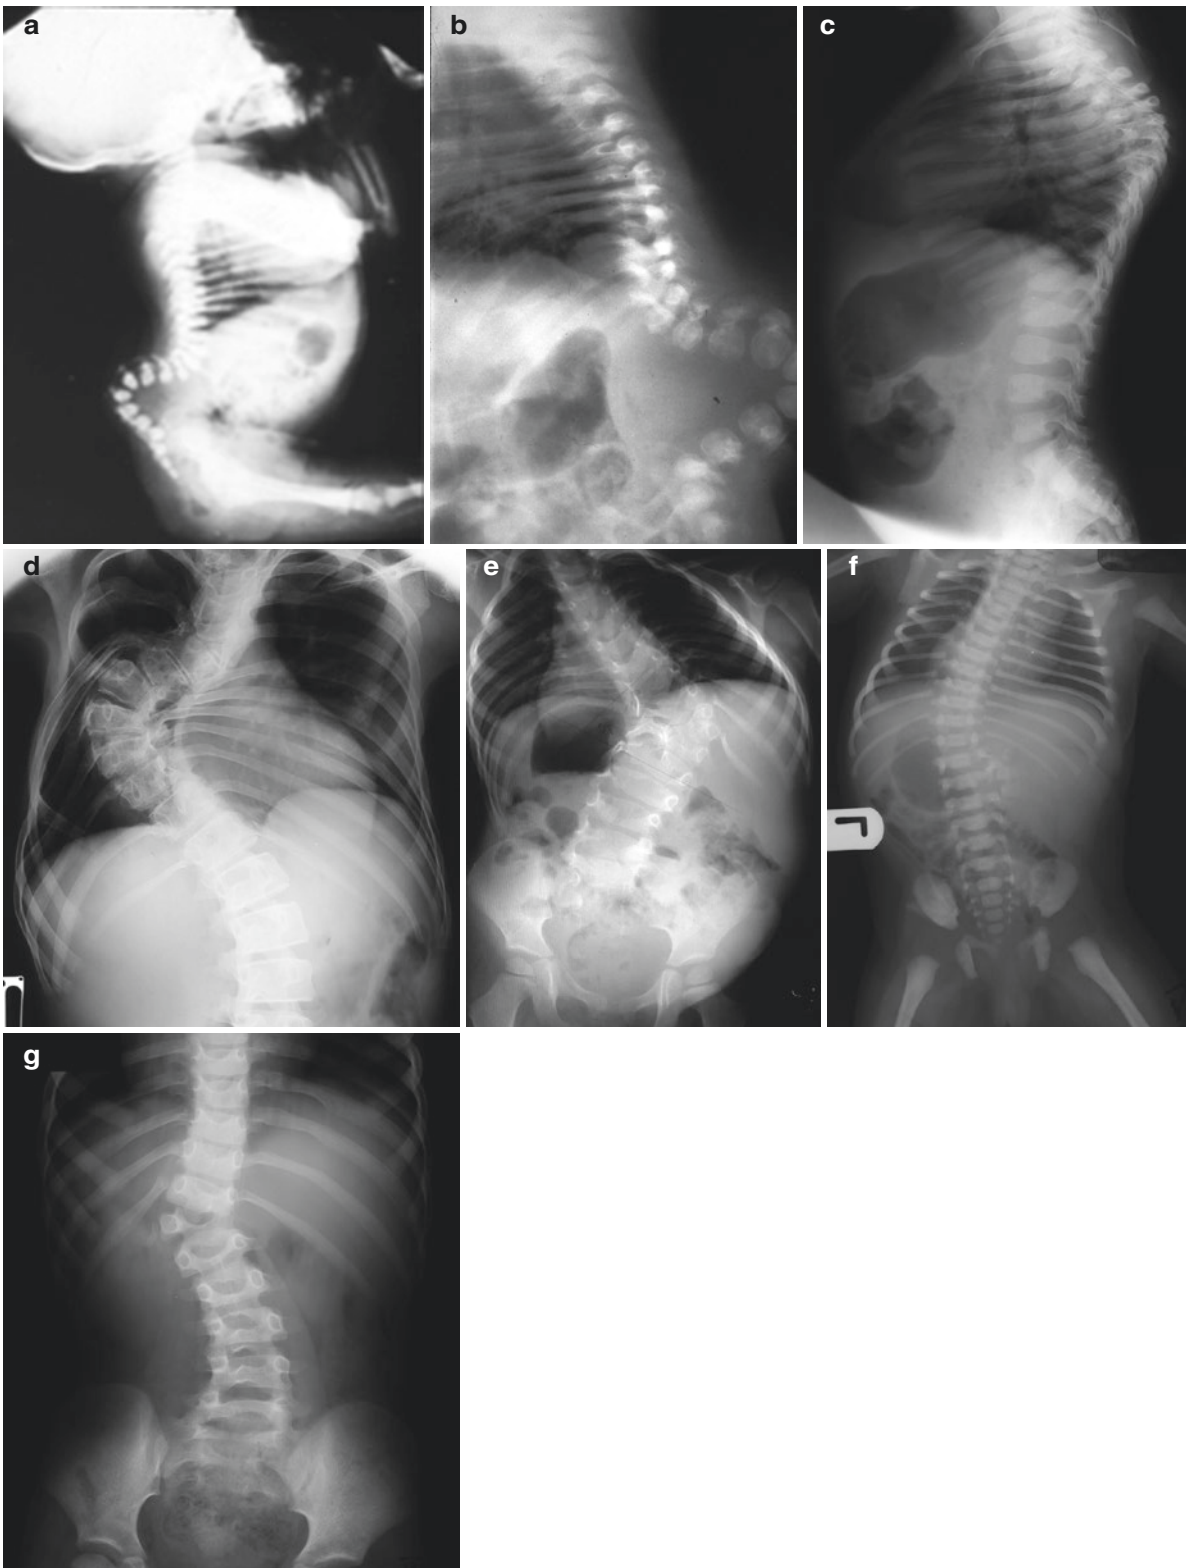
(a) Babygram showing a lateral view of a severe gibbus, Kyphosis of the lumbar spine. (b) Severe Kyphosis of the lumbar spine with an acute angle, seen on this plain X-ray. (c) Plain X-ray lateral view showing a mid-thoracic kyphosis. (d) Plain X-ray showing a severe mid-thoracic scoliosis. (e) Plain X-ray of the spine showing
